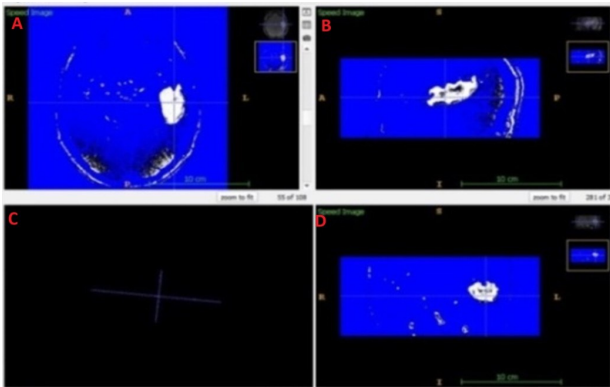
This figure shows the segmentation of white and grey matter in MRI images using ITK-SNAP. The clear boundaries of each tissue type are highlighted, aiding in the precise identification of brain structures (A, B, C and D).
